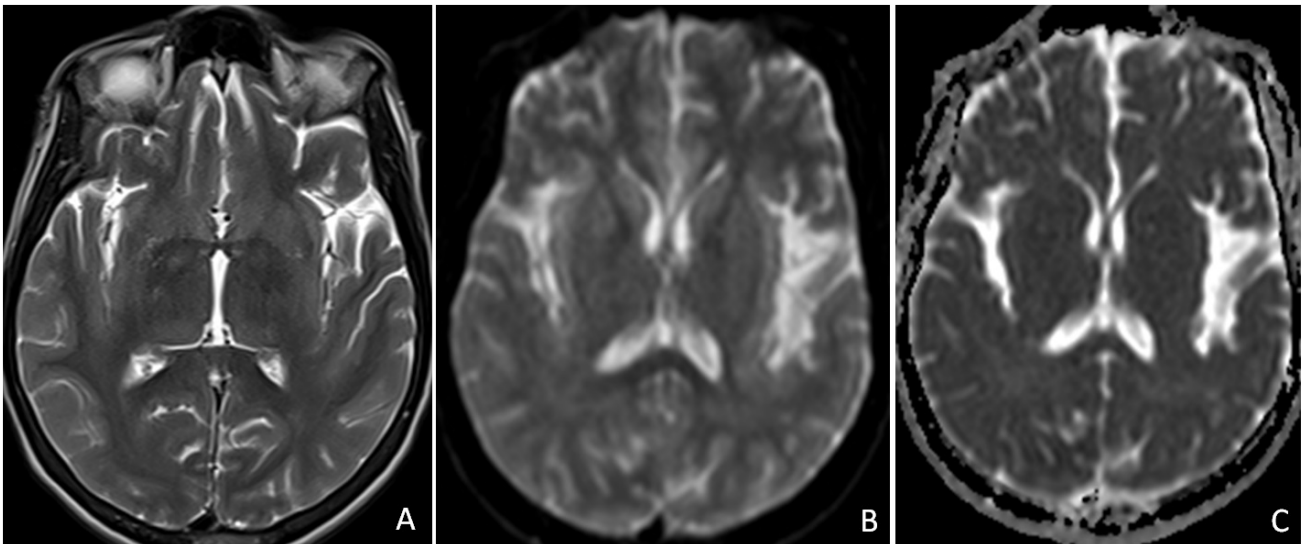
Axial T2W and DWI MRI obtained a month later shows resolution of abnormalities. The case report has written in an anonymous characteristic, thus secret and detailed data about the patient has removed. Editor and reviewers can know and see these detailed data. These data are backed up by editor and by reviewers.
